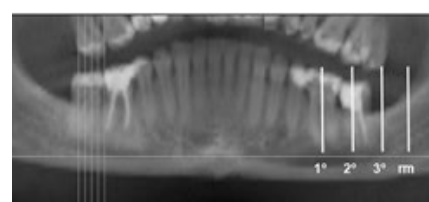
Example of a panoramic cut and radiographic anatomic distances in the mandibular retromolar (rm) and molar regions, and image of reference of median transaxial cuts.
